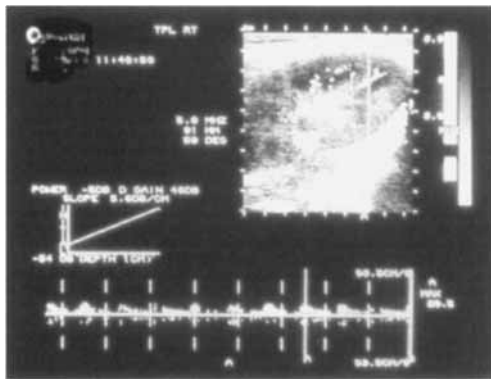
Color flow image of a normal renal transplant shows flow in the interlobar, segmental, and main renal arteries. With DCFI, the ability to image small vessels allows precise measurement of the Doppler angle, allowing accurate velocity measurements, as indicated in the sampling of the interlobar vessel in this patient.
